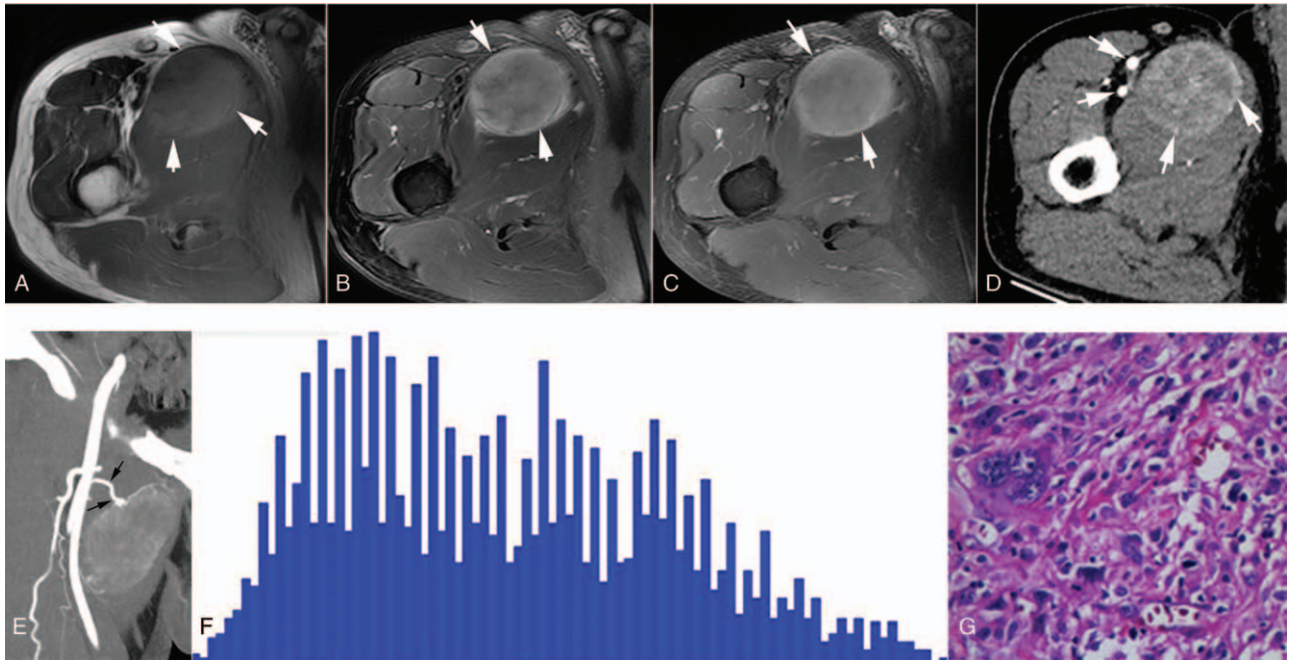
A 62-year-old man with a mass in the right thigh. The tumor was hyperintense on the T1-weighted MR image (A, arrows), and heterogeneously hyperintense on the T2-weighted image (B, arrows). The enhancement was heterogeneous on the contrast-enhanced T1-weighted image (C, arrows) and the CTA source image (D, arrows). The main arteries were free from tumor, and the feeding artery was well-depicted on reconstructed maximum intensity projection CTA images (E, arrows). Kurtosis, skewness, and inhomogeneity derived from the histogram (F) were -0.68 , 0.48 , and 0.54 , respectively. The pathology showed a leiomyosarcoma (G). CTA=computed tomography angiography.
